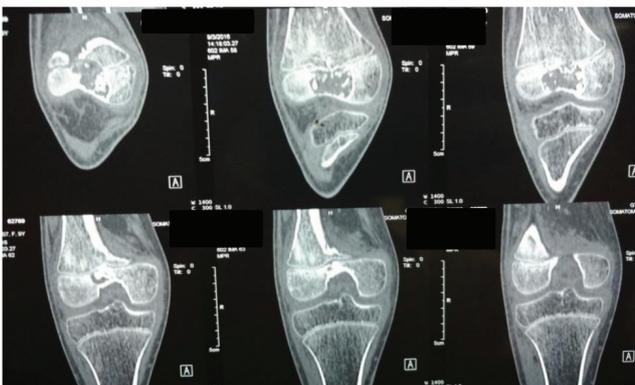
CT scan confirming subchondral extension of the tumor in one of the section (upper row far right).
